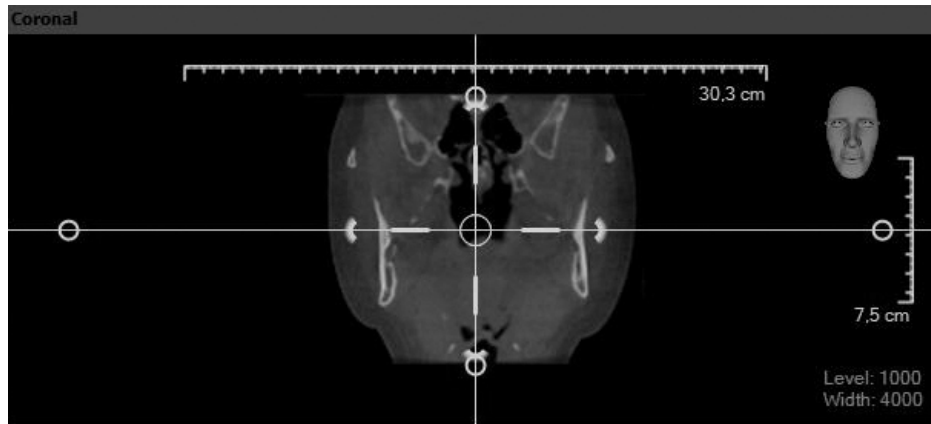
An example of a coronal slice of CBCT image
